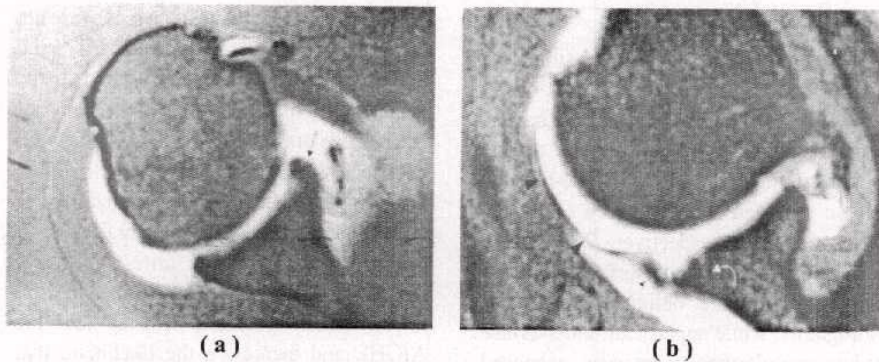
Detection of anterior labrum detachment with ABER position in a 28-year-old man who had an anterior traumatic shoulder dislocation. (a) Standard axial T1-weighted MR arthrogram: The anterior labrum (arrow) appears intact, (b) ABER oblique axial T1-weighted MR arthrogram clearly demonstrating the avulsed anterior labrum (arrow) displaced away from the underlying bony glenoid by the attached AIGHL (arrowheads). An anterior bony glenoid fissure fracture (curved arrow) is also seen on the oblique axial image.
